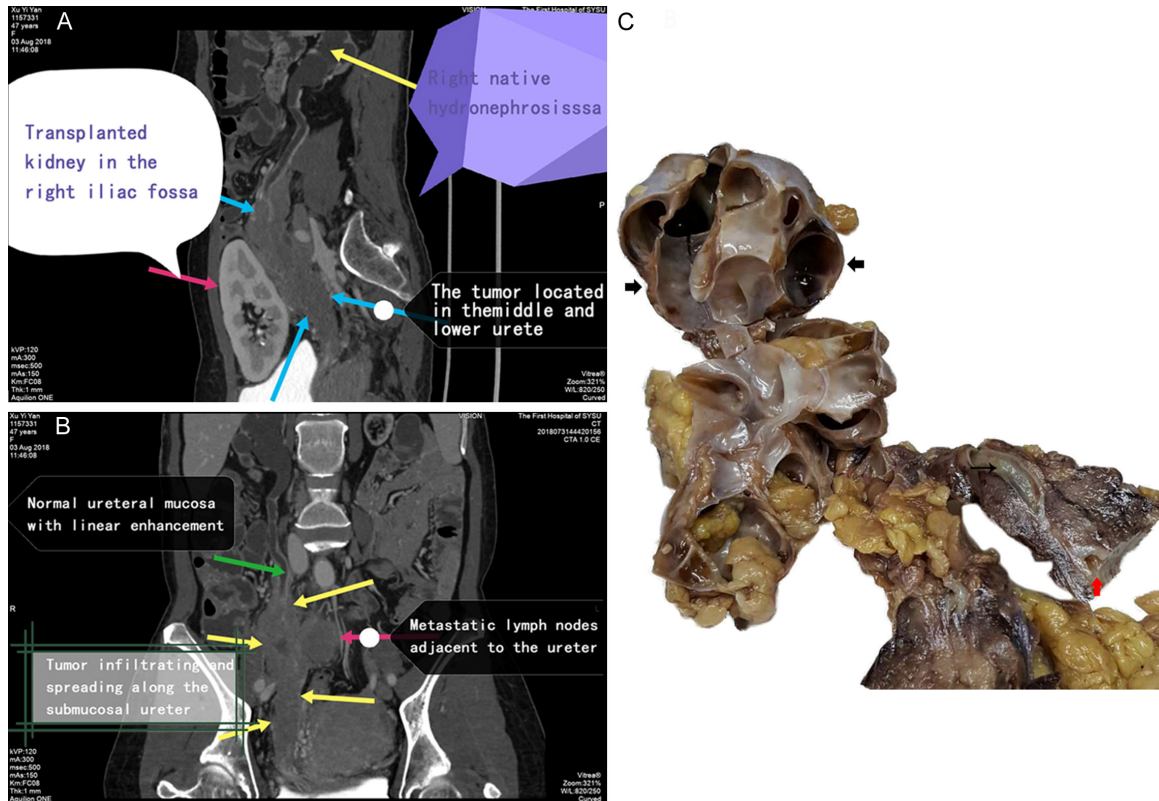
CT and gross images of the mass. A. The sagittal view demonstrates that the tumor in the middle and lower segment of the ureter was close to the right transplanted kidney, but not invaded. B. Coronal view shows the right middle and lower segment of the ureter and the adjacent metastatic lymph nodes, and the right upper segment of the ureter and hydronephrosis dilatation of pelvic obstruction. C. Cut section of excised tumor showing the mucosa of thickened ureter (red thick arrow) was smooth with no ulcer lesions and a protuberant exogenous mass (black thin arrow). The renal section is multilocular cystic (black thick arrow).
